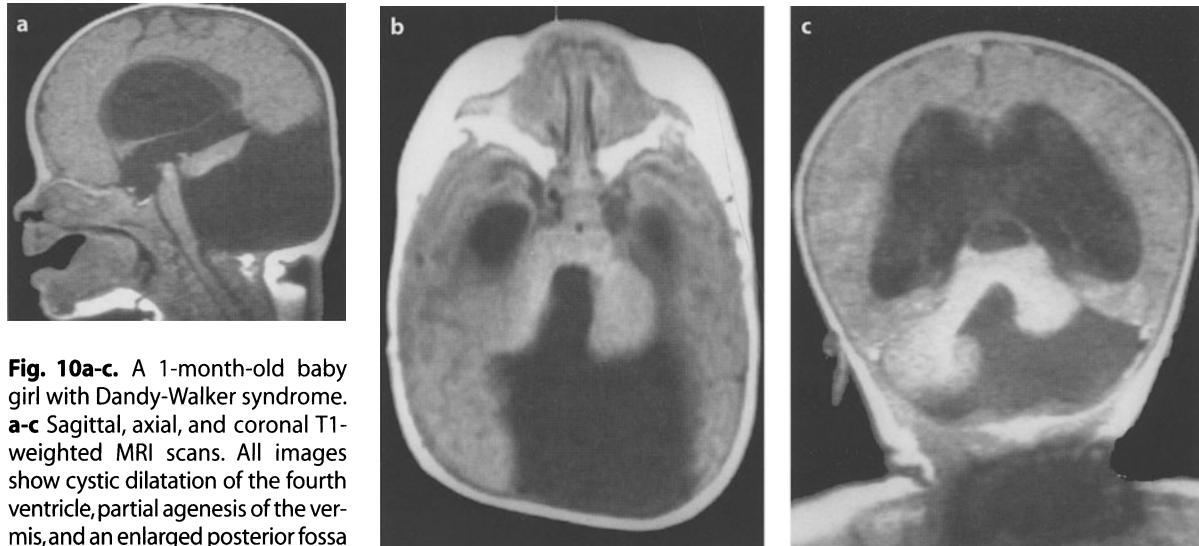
A 1-month-old baby girl with Dandy-Walker syndrome. a-c Sagittal, axial, and coronal T1-weighted MRI scans. All images show cystic dilatation of the fourth ventricle, partial agenesis of the vermis, and an enlarged posterior fossa with elevation of the tentorium
